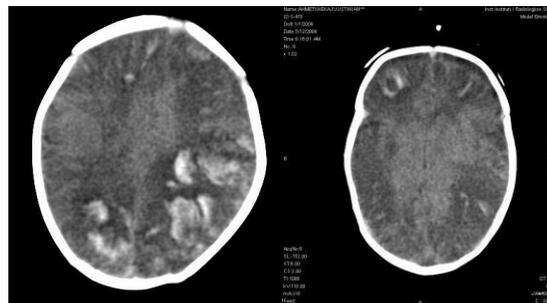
CT images showing multiple intracerebral bleedings and abscesses.
